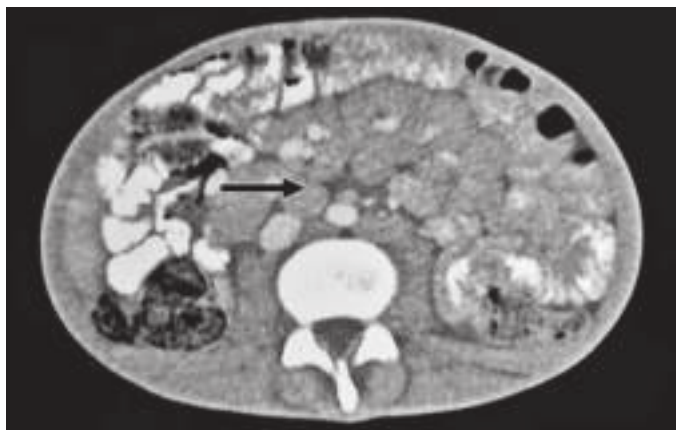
Abdominal lymph nodes in acute lymphoblastic leukemia (ALL) patient on CT scan. Transverse image on CT scan is showing lymph nodes (shown by arrow) in the abdomen.
